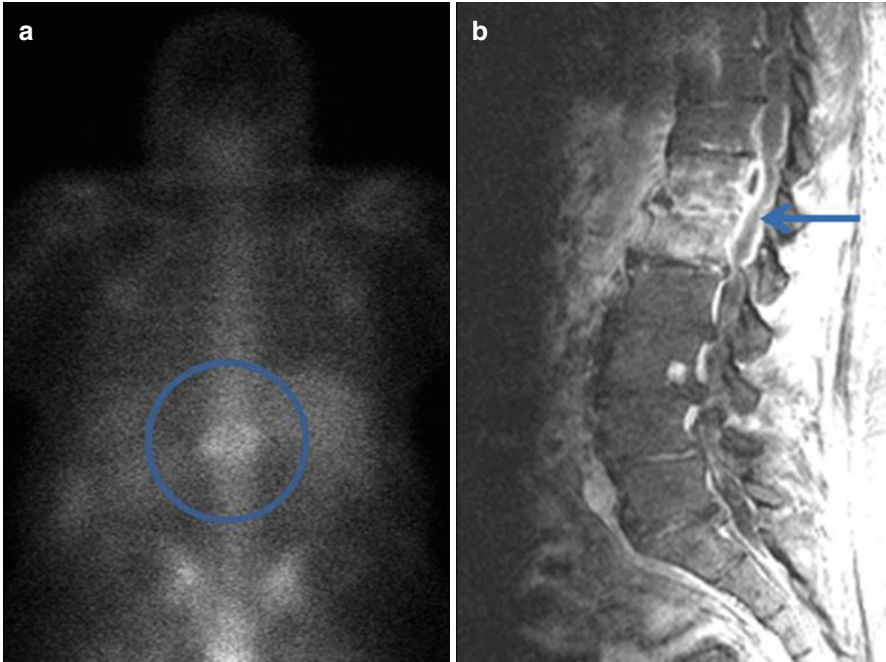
Osteomyelitis/discitis in an iv drug abuser with fevers and leukocytosis of unknown source. The Gallium-67 scan (a) shows the radiotracer accumulating in the T12-L1 region (blue circle). The T1-weighted post-contrast MRI image (b) demonstrates a robust enhancement of the vertebral bodies, disc, and paravertebral soft tissues (blue arrow) consistent with osteomyelitis and discitis
